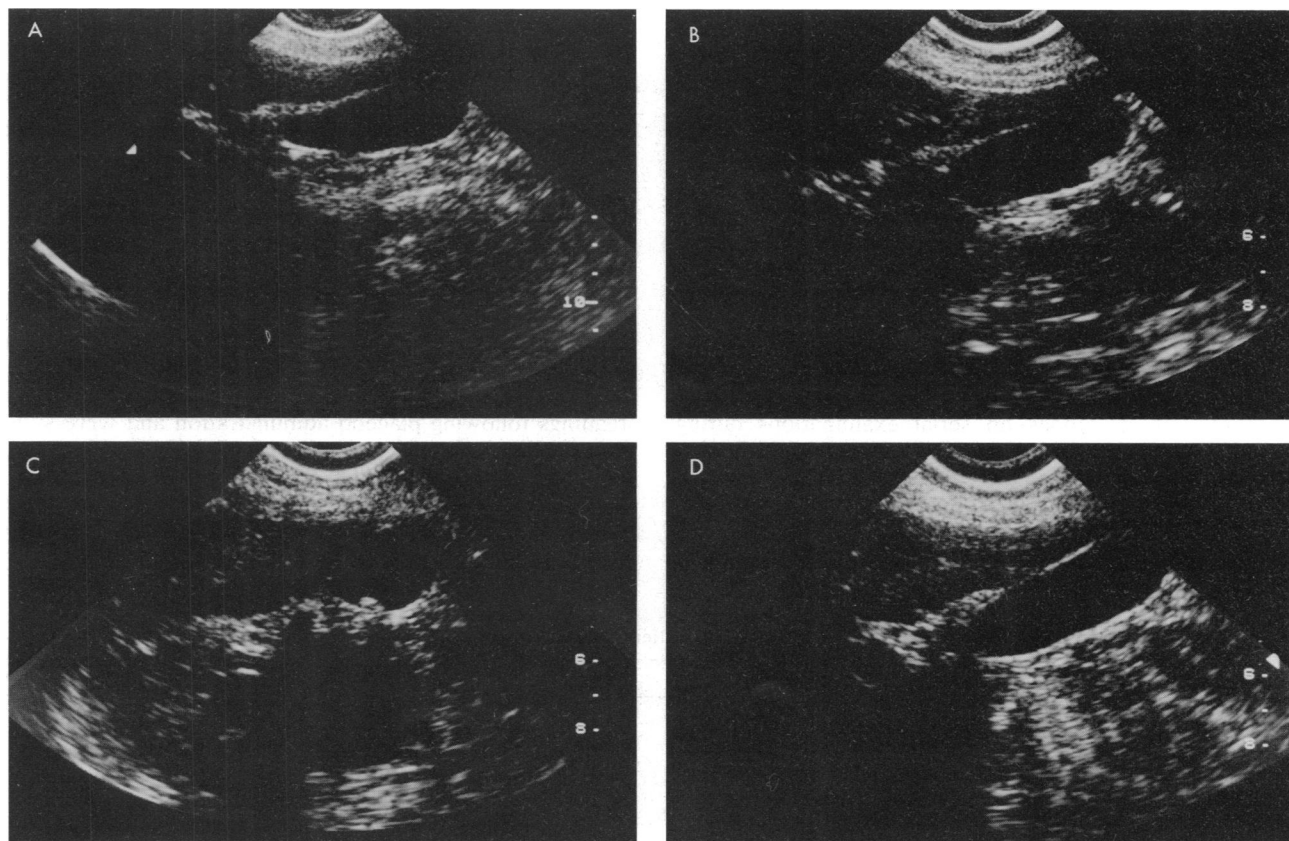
Sequential gallbladder sonograms for patient 38 on days 1 (A) and 14 (B and C) of therapy and at the time of follow-up (D).
